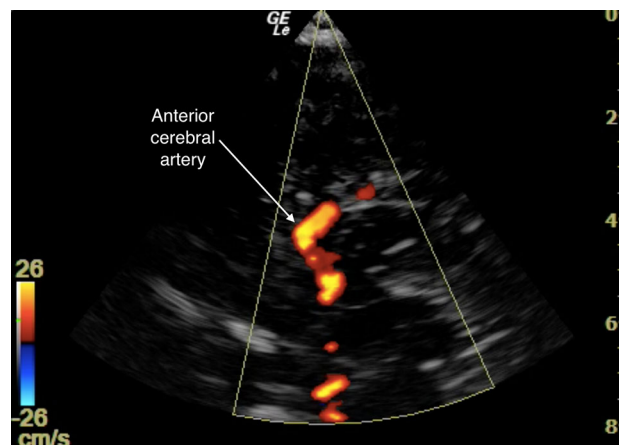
Transcranial Doppler of the anterior cerebral artery
